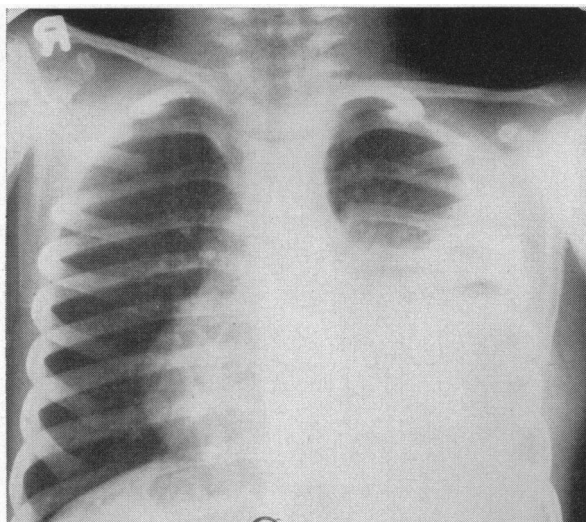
(Case 3).—Postoperative x-ray film of chest showing persistent left chylothorax despite repeated thoracenteses.
